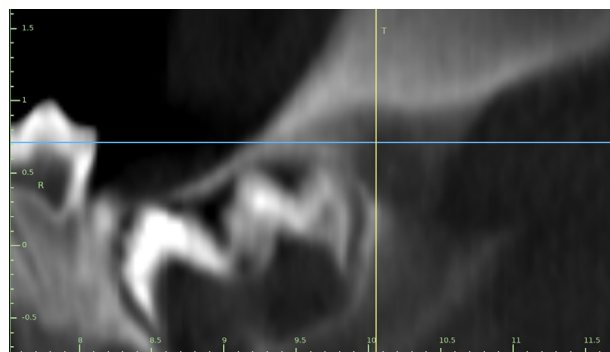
Radiographic view of tooth bud #18 (at crosshairs) at 14-days post ablation. Treatment site shows active bone regeneration. Photo credit: TriAgenics, Inc.
